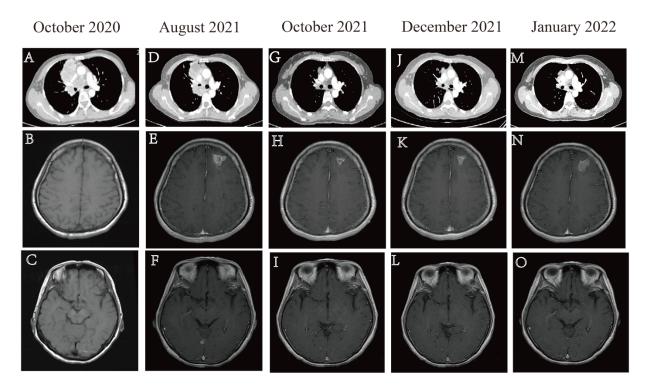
Chest CT revealed a lung lesion in the right lobe(October 2020) (A) and brain MRI revealed that there was no lesion in the brain at baseline (October 2020) (B,C); chest CT scan revealed the right lobe lesion PD after first-line TKI treatment (August 2021)(D) and brain MRI revealed multiple brain metastasis after first-line TKI treatment (August 2021) (E,F); chest CT and brain MRI showed PR after 2 cycles (October 2021) (G,H,I), confirmed PR after 4 cycles (December 2021) (J,K,L) second-line ABCP regimen, chest CT revealed the lung lesion continued PR(January 2022) (M), however the brain MRI revealed the brain lesion of frontal lobe was local progression (January 2022) (N,O), the overall evaluation was PR.
